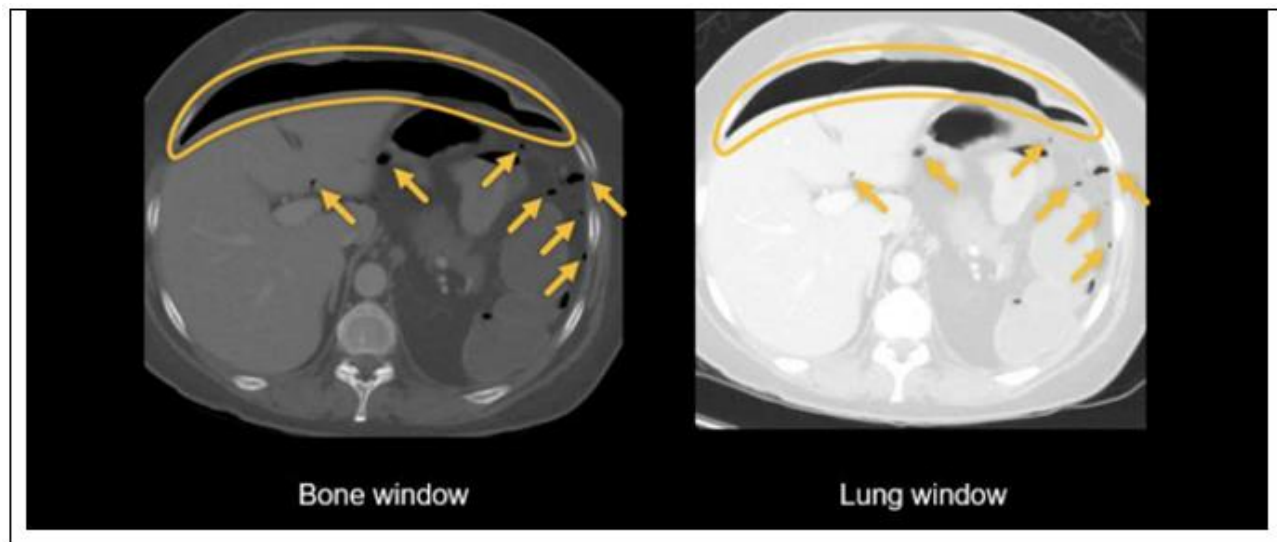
An example for pneumoperitoneum in computer tomography (CT). Pneumoperitoneum marked with yellow – lines and arrows. Bone and Lung window. Permission by Dr Mike Cadogan, <https://litfl.com/abdominal-ct-bowel-perforation/>
